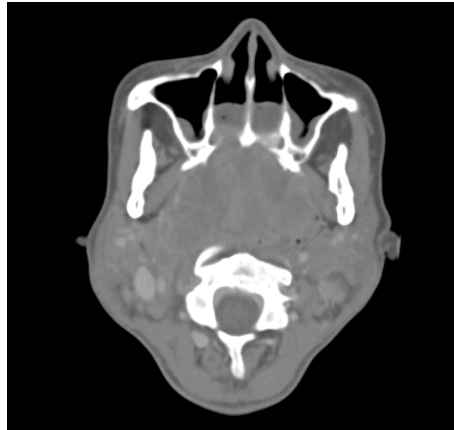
Axial plane. Computed tomography of the head. A large mass blocking the air flow at the bilateral nasal cavity is clearly visible.
